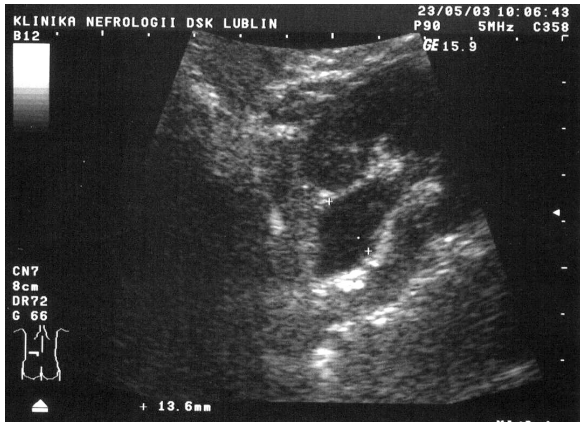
External renal pelvis with a diameter of 13 mm — transverse sonogram.
